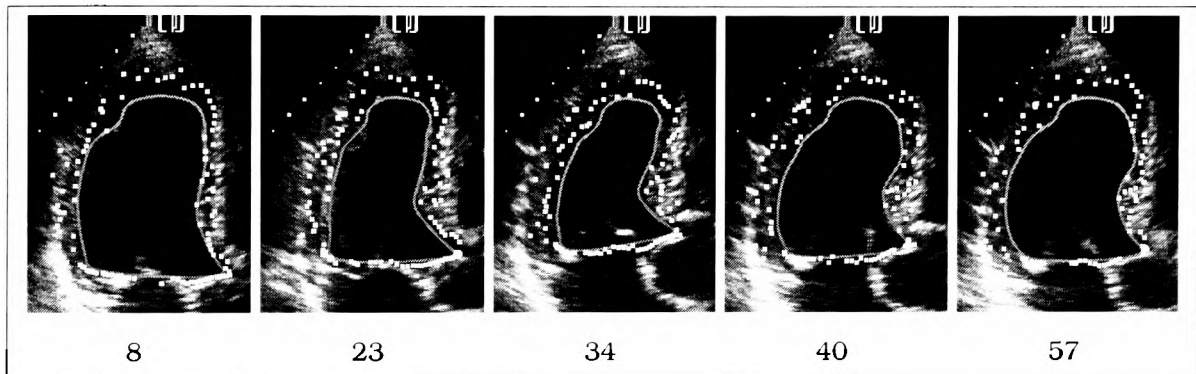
Epicardium estimation using a local phase step detection. Typical frames from an ultrasound sequence. The position of the endocardium is tracked (red). Search lines are cast, normal to this boundary, and a local phase step detector was applied. The largest feature response along the search line is shown (cyan). We can see that this feature detector is not good enough. Note: The measurements along the mitral valve region are fixed to be the same for the endocardium and epicardium estimation.
